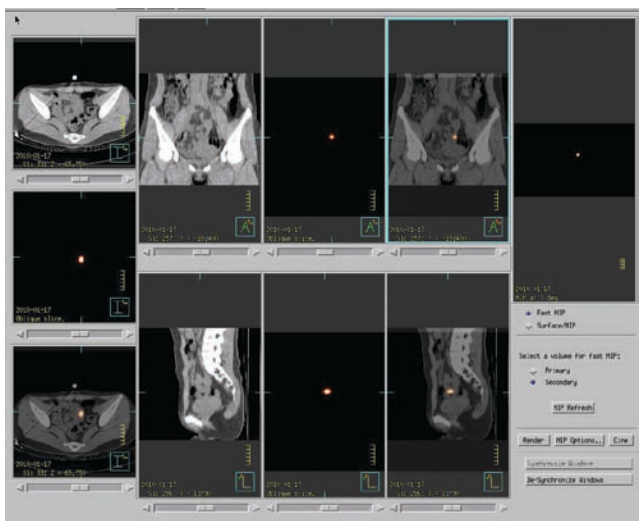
Co-registered SPECT/CT images demonstrate regional heterogeneity of radioisotope uptakes in hypogastrium (8 h).
